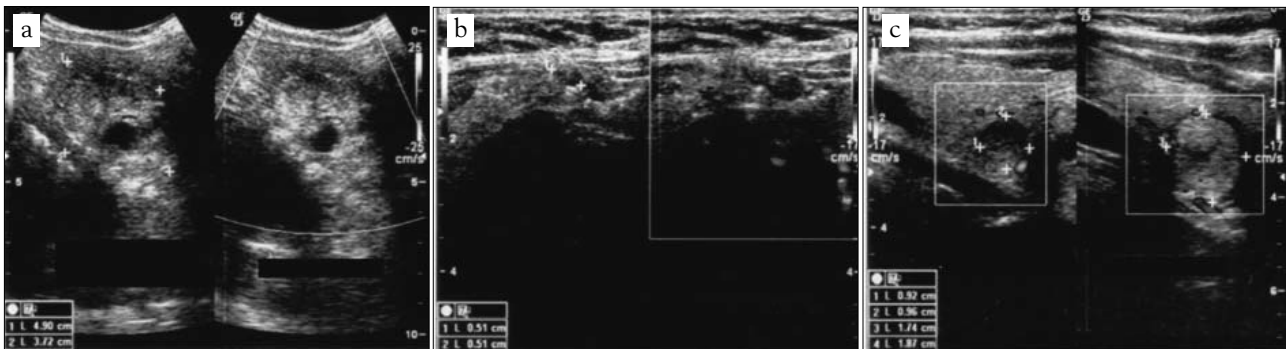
Thyroid ultrasound on a 65-year old male patient with a prior diagnosis of prostate cancer
